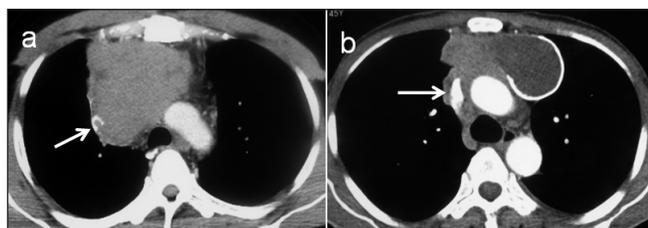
Contrast-enhanced computed tomography of the chest axial section showing invasion and encasement of superior vena cava in case 3 (a) and case 1 (b)
